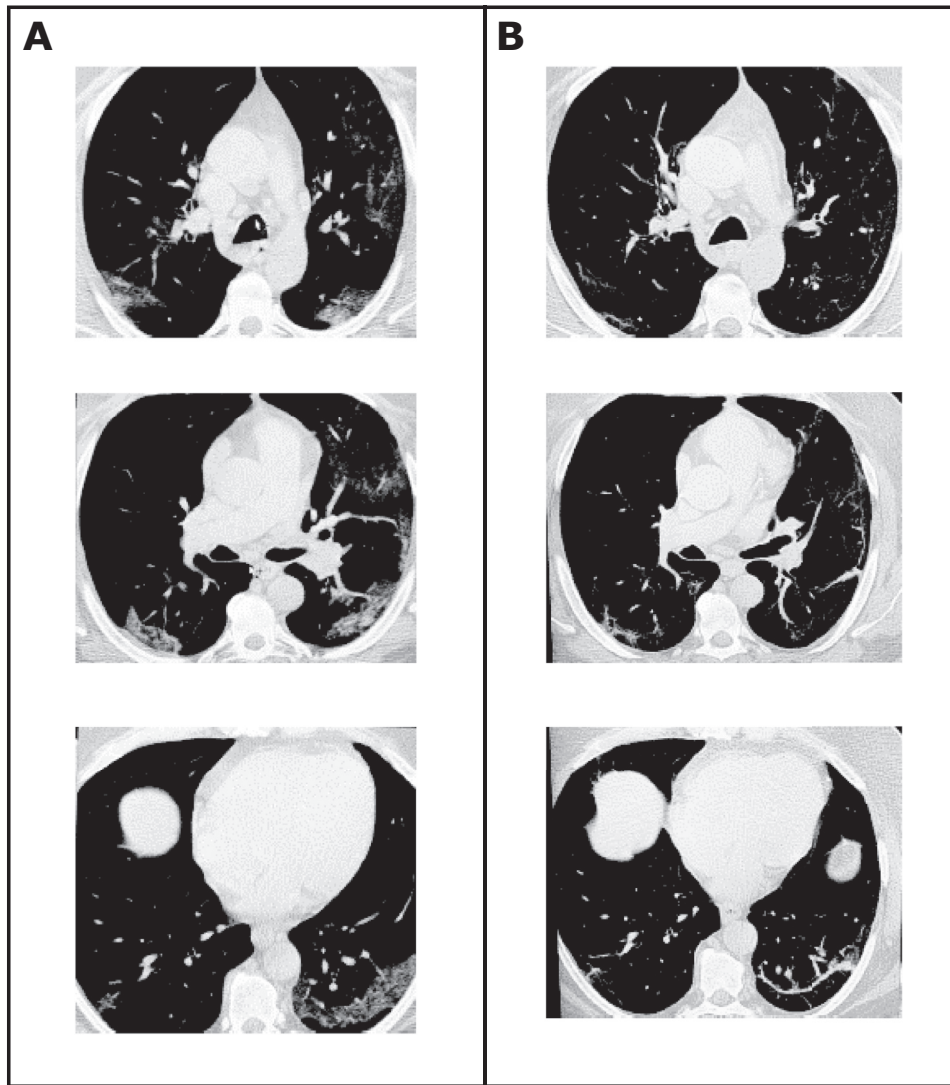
Representative chest radiographs from high-resolution CT scans at presentation (A) and after tocilizumab treatment (B) in three patients. At hospital admission, all patients had suspected COVID-19 and underwent high-resolution multidetector or conventional CT of the chest. Initial CT performed at presentation (A) showed alveolar and interstitial ground-glass opacities and areas of consolidation compatible with interstitial pneumonia indicative of COVID-19 infection and no evidence of pleural effusion. CT performed after tocilizumab treatment showed reduction of ground-glass opacities in all patients and reduction in areas of consolidation in some patients. CT, computed tomography.
